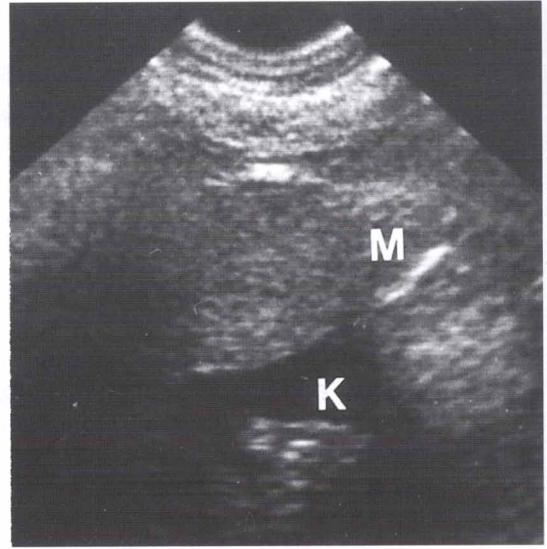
Abdominal transverse ultrasonogram shows a dumbbell-shaped, hyperechoic mass (M) saddling on the right kidney (K) and compressing it.
